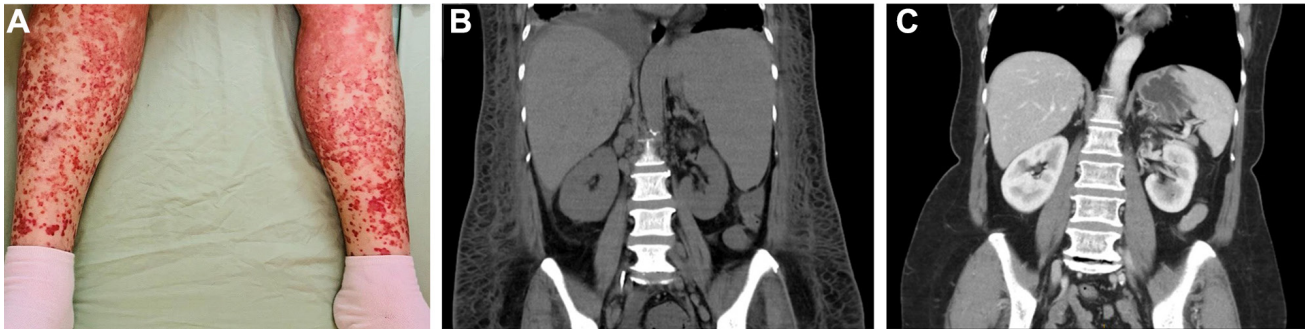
Cutaneous vasculitic rash and interval development of abdominal pathology on serial computed tomography. (A) Erythematous and purpuric non-blanchable maculopapular rash over the lower limbs upon admission. (B) Abdominal computed tomography on September 9, 2025, demonstrating panniculitis, ascites, hepatomegaly, splenomegaly (17.6 cm), and periaortic lymphadenopathy. (C) Abdominal computed tomography on January 23, 2025, showing no significant abnormalities.
